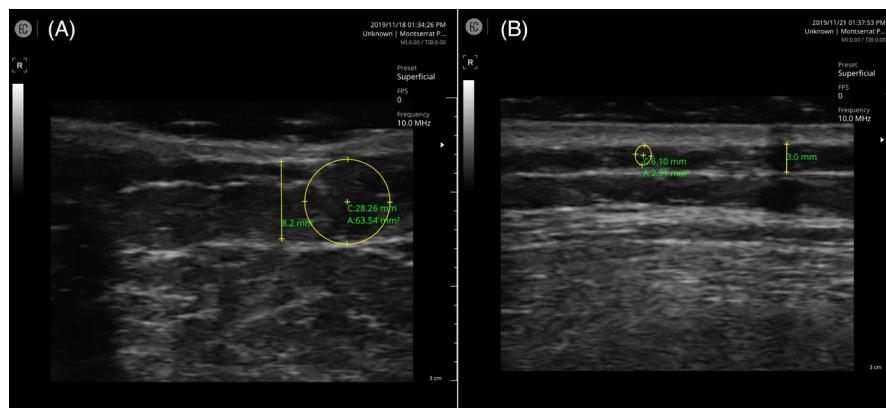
Ultrasonographic image of the central abdominal region before treatment (A) and 6 months after treatment (B). Besides the significant reduction in fat layer thickness, an important regeneration of collagen fibers can be observed
